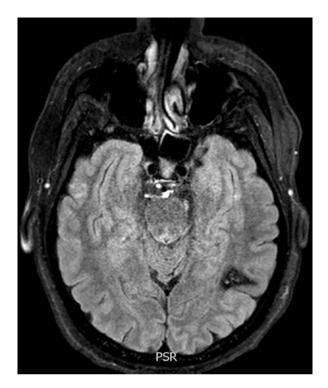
Axial cranial MRI, FLAIR sequence, detecting a 1.5 cm long cavernoma in the left temporal-parietal-occipital junction
